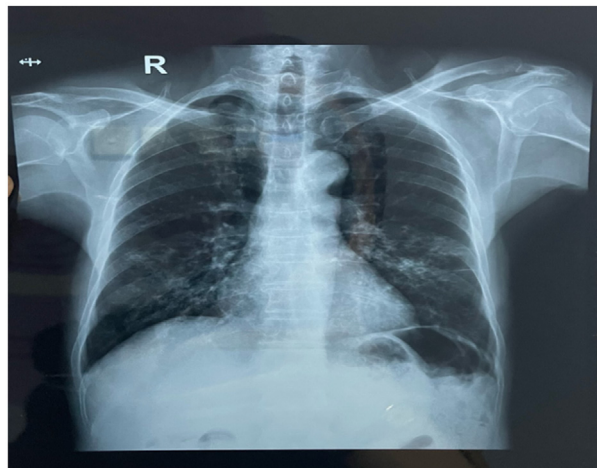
Chest x-ray (18th May 2022) suggesting pulmonary TB
